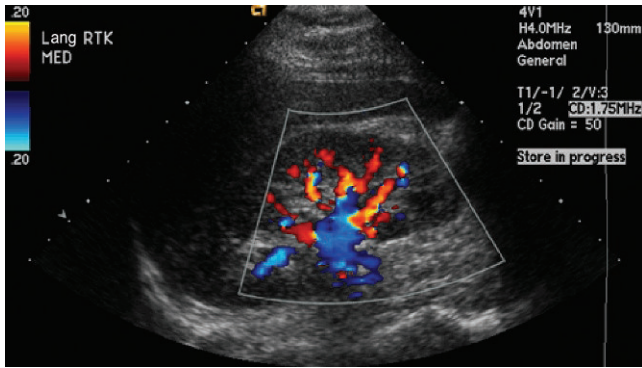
Longitudinal ultrasound with color Doppler of the right kidney shows that the right renal vein is patent. The IVC was also patent (not shown). In cases of right-sided varicocele, especially if acute, the kidney should be interrogated.
